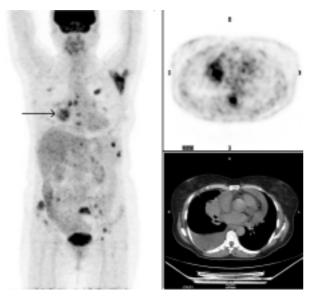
18F-FDG PET/CT Showing a Hypermetabolic Lesion in the Right Lung. See arrow on maximum intensity projection image on the left, transaxial PET and corresponding CT images on the right) in addition to multiple hypermetabolic bone metastases
